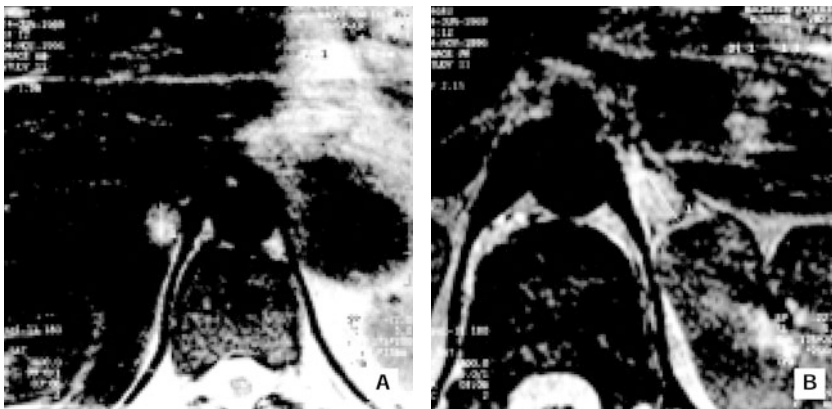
1B - Magnetic resonance images, demonstrating a nodule of 1.5 cm on the right adrenal gland and a mass of 1.7 cm on the left.
